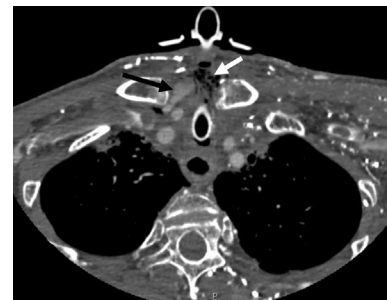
Computed tomography angiogram axial view. Black arrow points to an outpouching arising from the right common carotid artery suspicious for a pseudoaneurysm. White arrow points to peritracheal emphysema surrounding the lesion.
